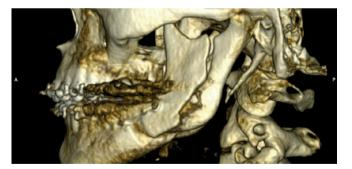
Cone Beam Computed Tomography (CB-CT) scan of a horizontal buccal plate fracture of the left side of the mandible during a BSSO, reaching the incisura semilunaris (figure 1; type Ia). The proximal and distal segment of the mandibula were eventually fixated with two bicortical screws on the lower border of the mandible (in this figure hidden behind the buccal segment), combined with plate fixation to attach the buccal segment.
